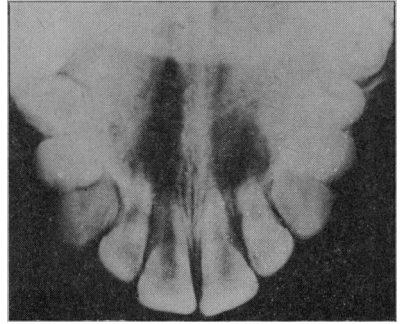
(Case II).—Original occlusal radiograph showing bilateral areas of rarefaction of the same extent in association with both lateral incisors.
